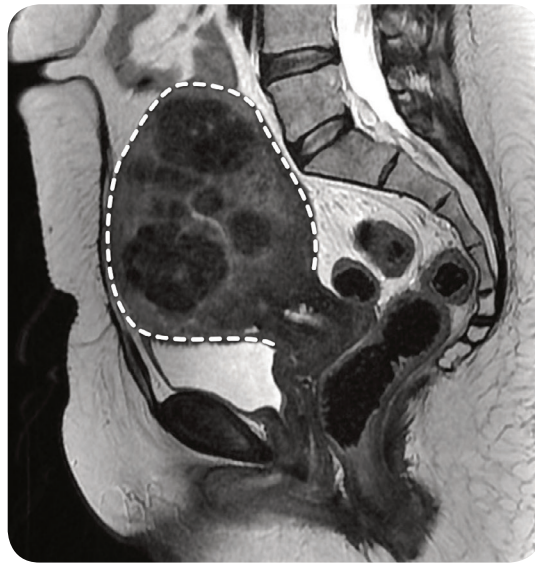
An MRI scan of the pelvis in the sagittal plane. The uterine corpus is outlined. The many hypodense objects within it are uterine fibroids.
